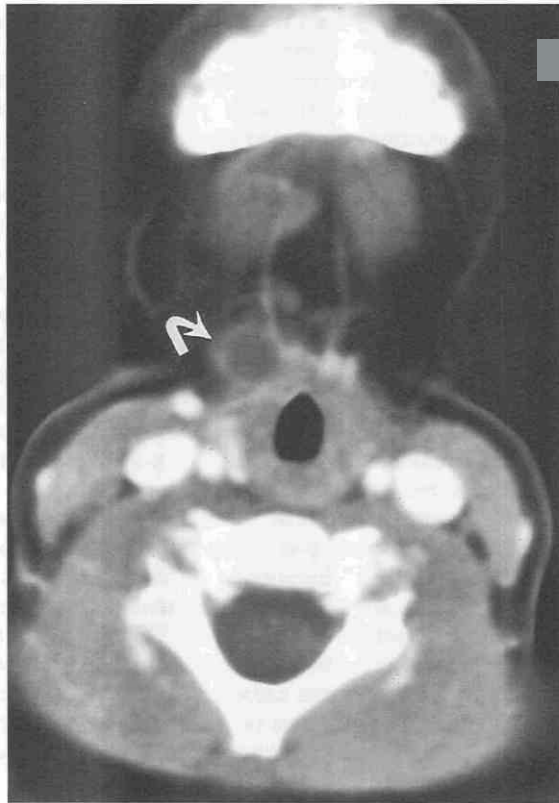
Dermoid cyst. Axial postcontrast CT scan. A well-defined mass of decreased attenuation lies in the anterior neck, slightly off midline (*curved arrow*). Attenuation values were 0 to -5 Hounsfield units (HU).
